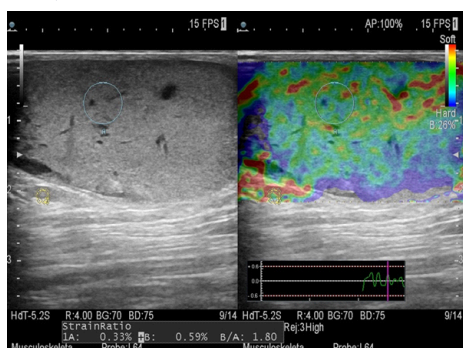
A patient presented with a gluteal swelling in subcutaneous plane (No vascularity was seen on doppler). On elastography soft colours were seen (red and green). Strain ratio was 1.8 suggestive of benign lesion. Sebaceous cyst was found on FNAC.
